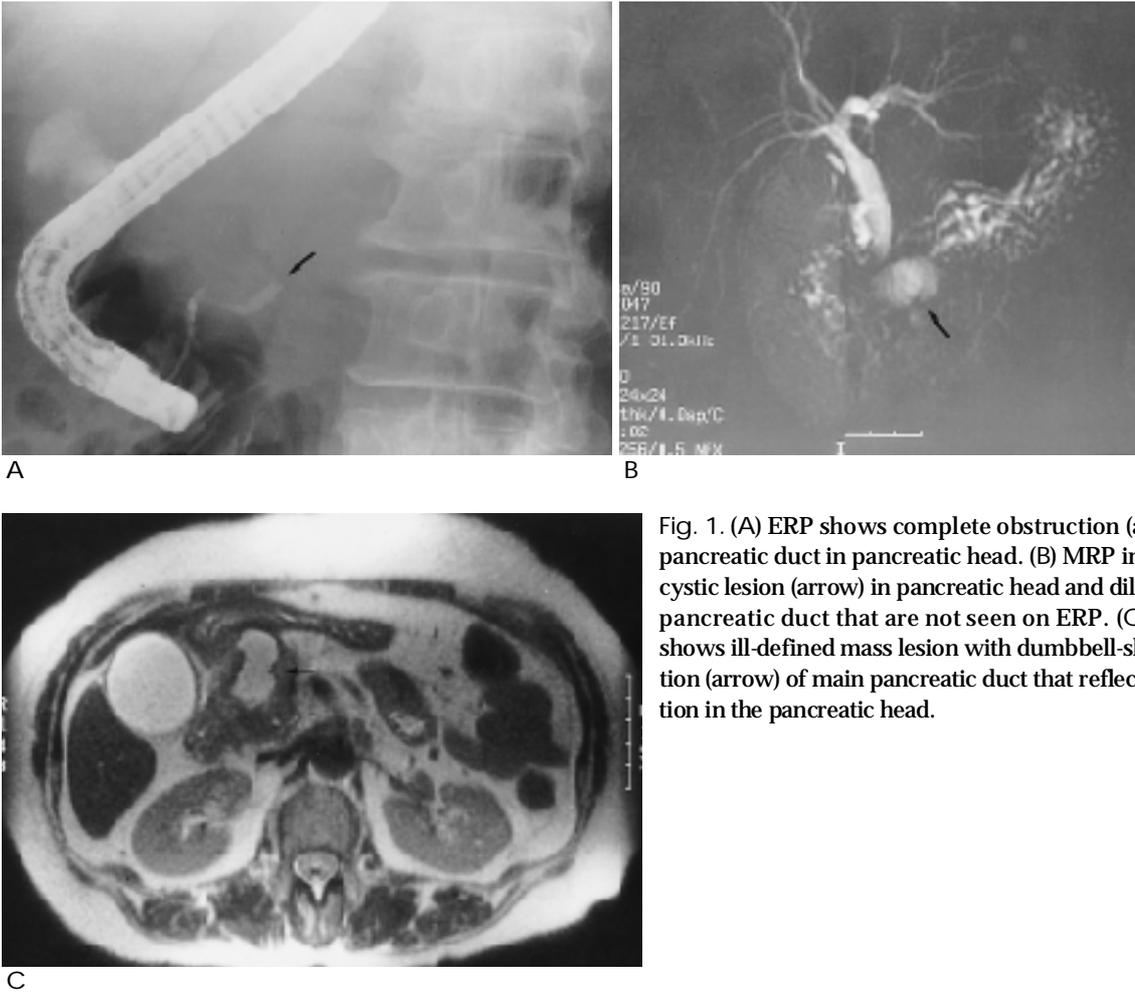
(A) ERP shows complete obstruction (arrow) of the main pancreatic duct in pancreatic head. (B) MRP image demonstrates cystic lesion (arrow) in pancreatic head and dilatation of proximal pancreatic duct that are not seen on ERP. (C) Axial MR image shows ill-defined mass lesion with dumbbell-shaped cystic dilatation (arrow) of main pancreatic duct that reflects tumoral obstruction in the pancreatic head.
